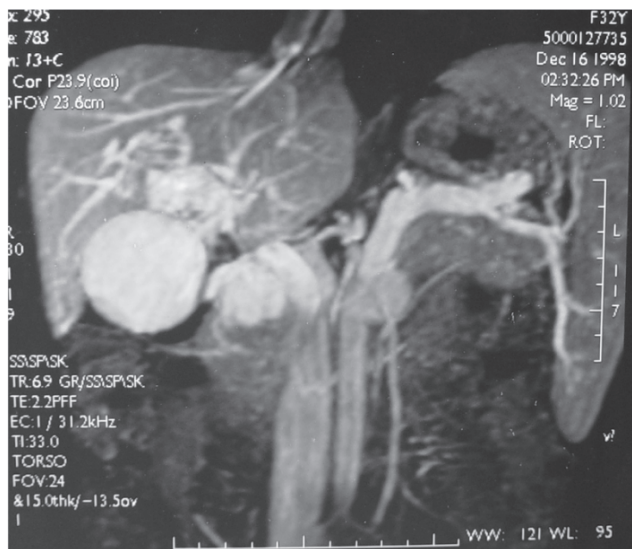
Nuclear magnetic resonance, in a sagittal cut, showing the dilated portal vein with the maximum diameter being the same as that revealed by computed tomography. Performed in 1998.
